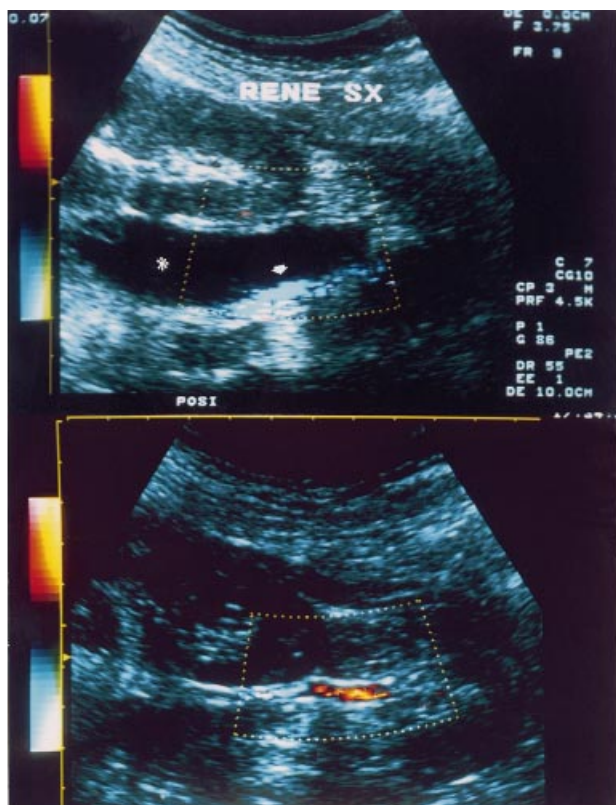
(Upper): Colour-Doppler mapping on longitudinal posterior scan. Evidence of perirenal haematoma (asterisk) and of the anomalous vessel in front of it (arrow). (Lower): Colour-Doppler after resolution of the haematoma. The anomalous vessel is closely located near the lower pole of the kidney.
